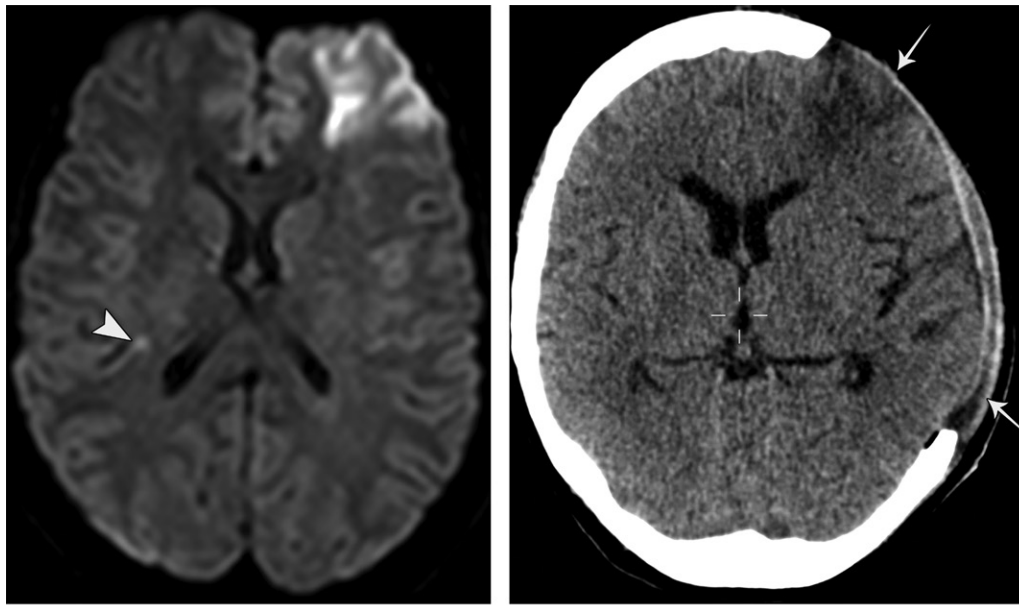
Extracranial hernia. (a) Axial diffusion-weighted image shows an acute infarction in the left frontal lobe. Also note the small focus on the right (arrowhead). A few days later, the patient developed vasogenic brain edema, and decompressive craniectomy was performed. (b) Axial CT image after craniectomy shows brain parenchyma herniating through the defect of the frontal and temporal lobes (arrows). The sylvian fissure is enlarged, and the frontal and occipital horns of the left lateral ventricle are retracted.
